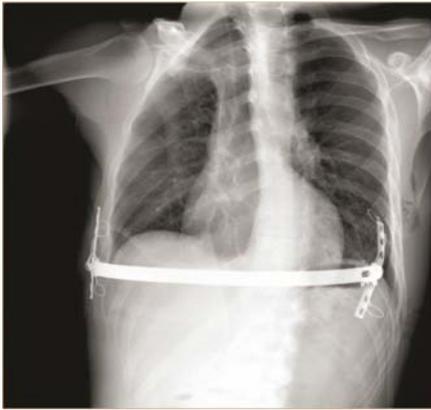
Chest X-ray oblique view for reverse Nuss with moon bridge stabilization.
